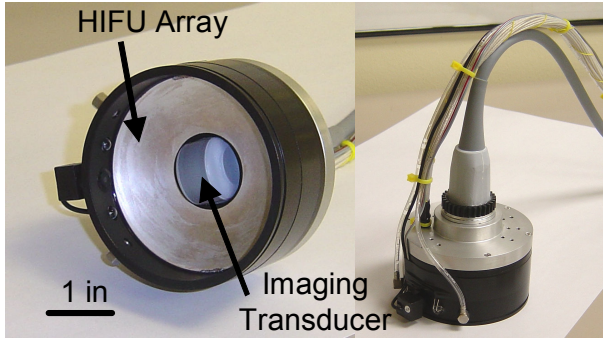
The applicator houses an ultrasound / Doppler imaging transducer for diagnosis and the annular HIFU treatment array.
